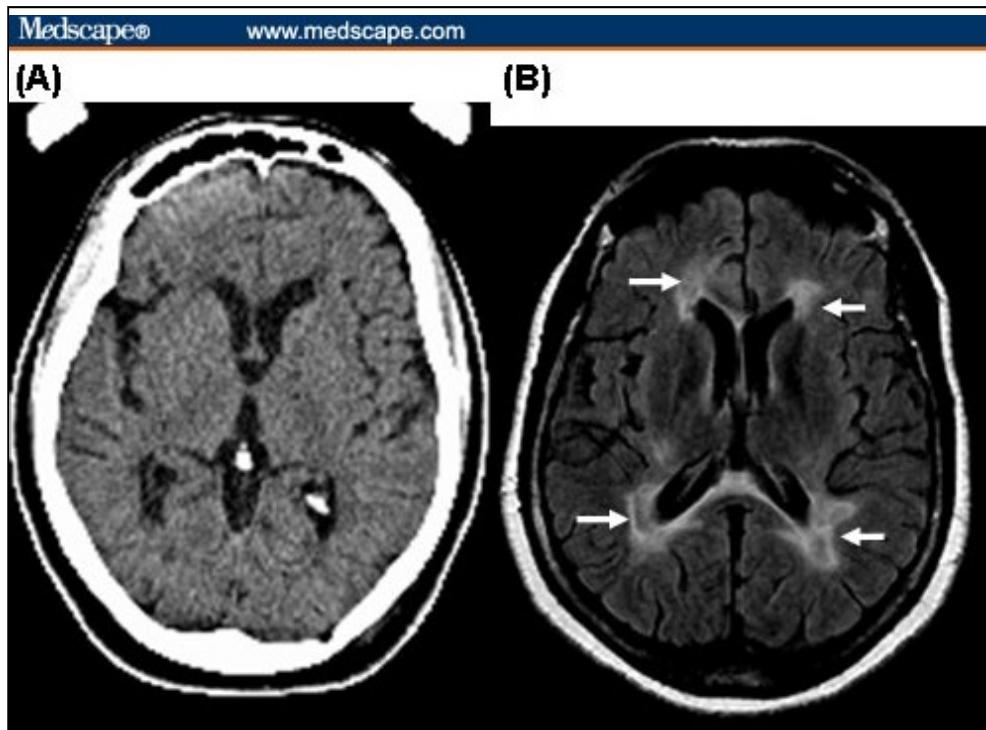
Comparison of CT and MRI images. (A) CT scan and (B) MRI showing the increased sensitivity that MRI adds in visualizing brain lesions, such as those in MS (arrows).
